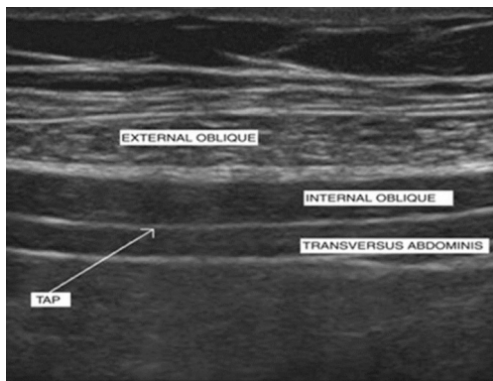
Ultrasound image showing the plane of injection between internal oblique and transverse abdominis.
